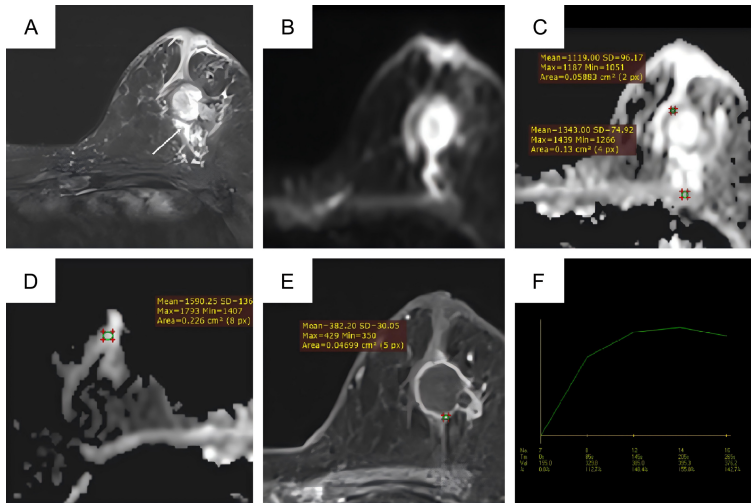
Representative images of a 55-year-old woman with triple-negative breast cancer (TNBC). A. Axial fat-suppressed T2-weighted image reveals an irregular mass with hyperintensity (suggesting cystic necrosis) and peritumoral edema (white arrow). B. Diffusion-weighted imaging (DWI) demonstrates high signal intensity. C. On the apparent diffusion coefficient (ADC) map, the mean ADC value of the lesion is $1.119 \times 10^{-3} \text{ mm}^2/\text{s}$, and the rADC1 (lesion/pectoralis major muscle) is 0.83. D. On the ADC map, the rADC2 (lesion/contralateral normal gland) is 0.70. E. Early-phase dynamic contrast-enhanced MRI (DCE-MRI) depicts distinct rim enhancement. F. The time-intensity curve (TIC) exhibits a plateau pattern (Type II).
